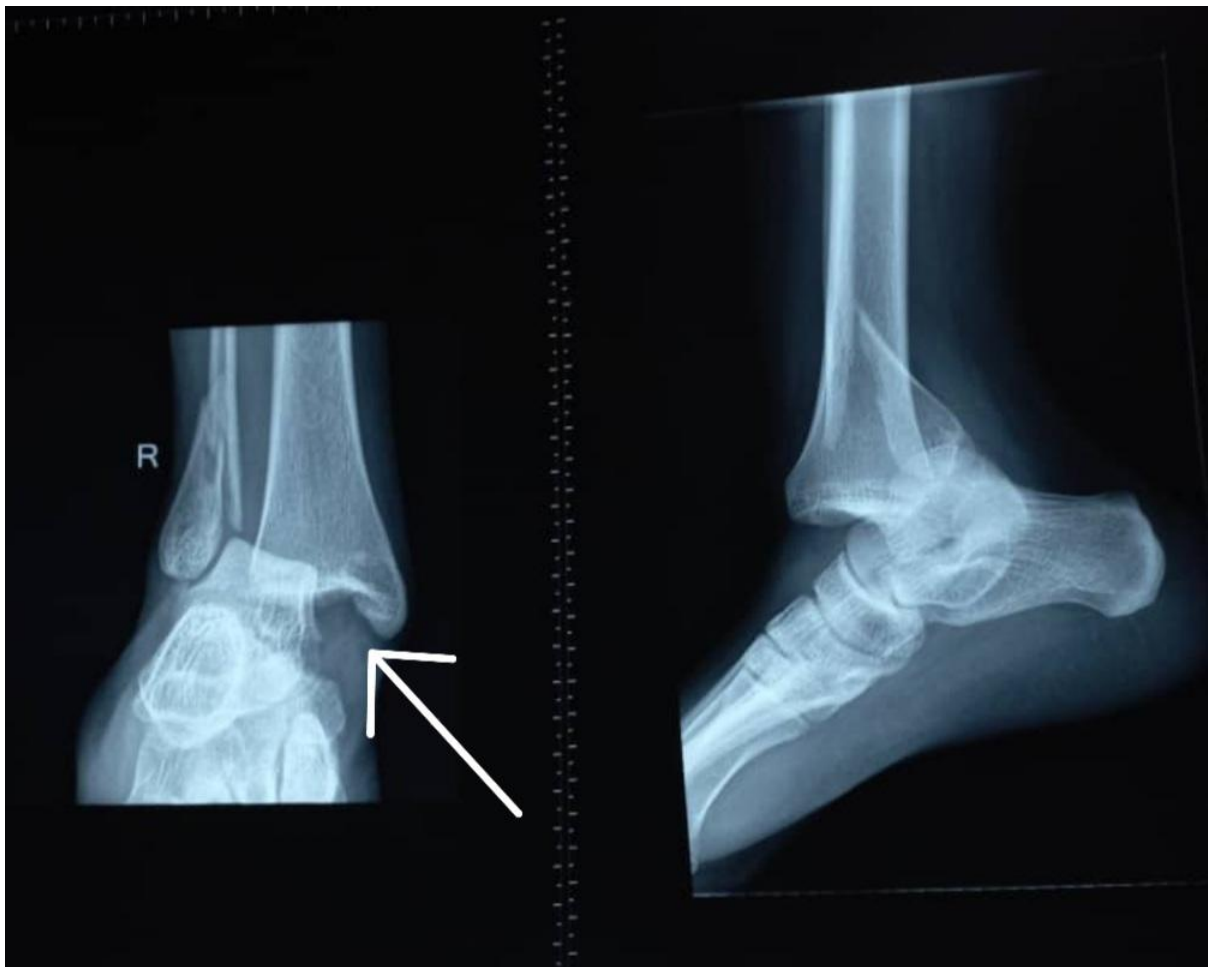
Anterior posterior and lateral radiograph showing posteriorly displaced talus and the arrow represents the “Axilla sign” present at the medial malleolus characteristic of Bosworth fracture.
